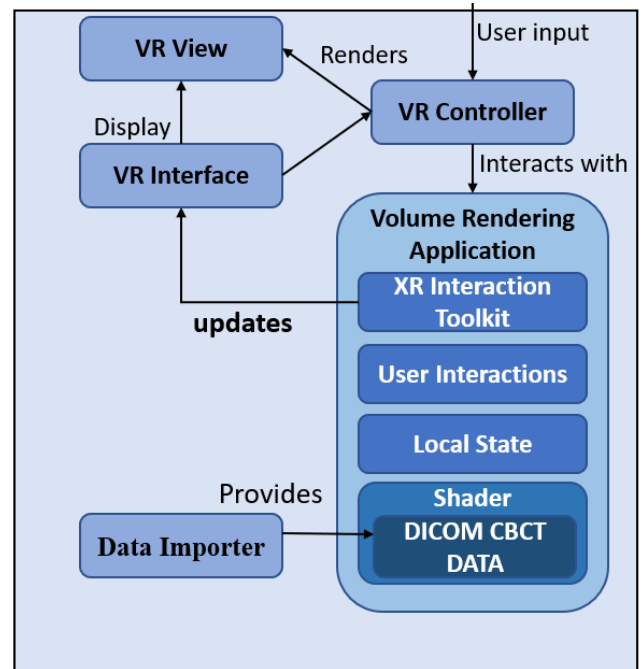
The Model-View-Controller (MVC) design pattern of the proposed Unity-based VR framework using Direct Volume Rendering for CBCT visualization.
